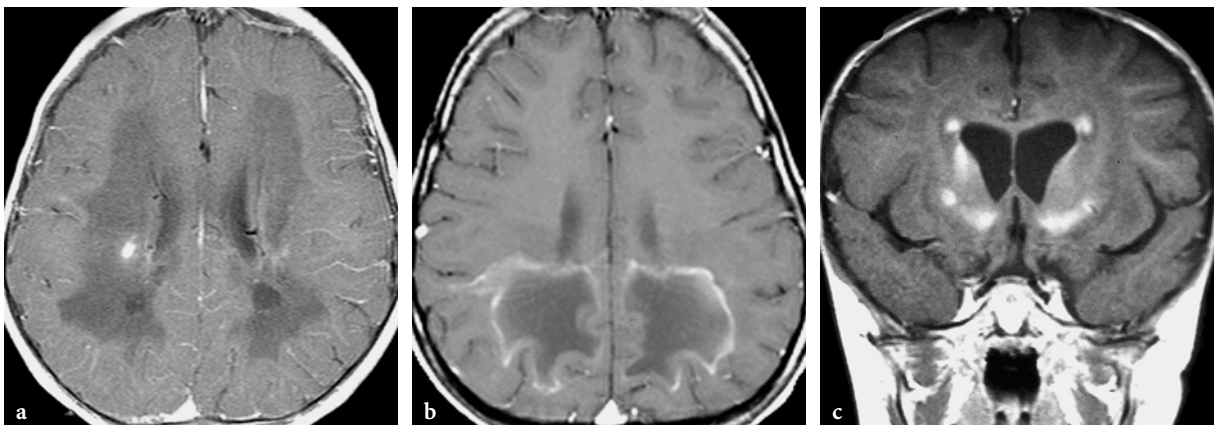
Enhancement patterns on postcontrast images in leukodystrophies. a Gd-enhanced axial T1-weighted spin-echo image in a 1-year-old male patient with Krabbe disease. Patchy enhancement is seen in the deep, periventricular white matter. b Gd-enhanced axial T1-weighted spin-echo image in a 12-year-old boy with X-linked adrenoleukodystrophy. The image shows typical peripheral enhancement around the demyelinated central, burned-out zone. c Gd-enhanced coronal T1-weighted spin-echo image in a 3-year-old female patient with Alexander disease. Enhancement is seen in the frontal periventricular white matter and at the level of the basal ganglia (courtesy of Dr. K. Chong, London, United Kingdom)
